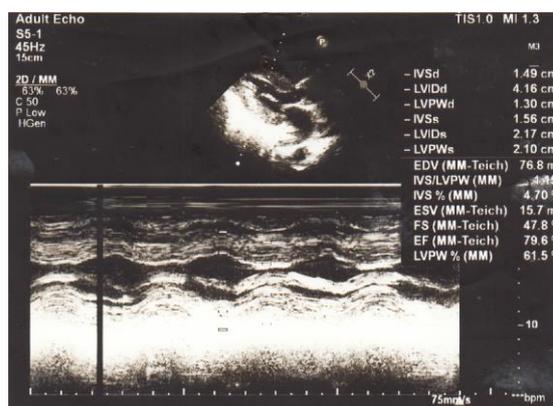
2D Echocardiography showed moderate concentric left ventricular hypertrophy and diastolic dysfunction.
